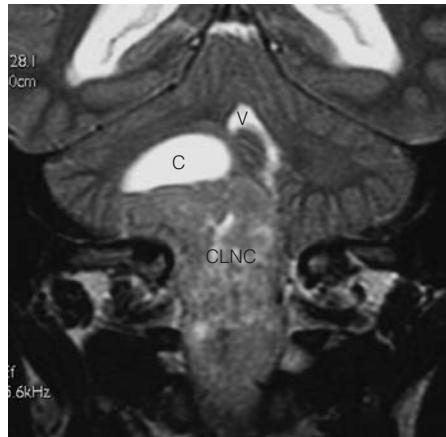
T2-weighted MRI of a cerebellar liponeurocytoma (CLNC) with an adjacent cyst (C) and compression of the fourth ventricle (V).
